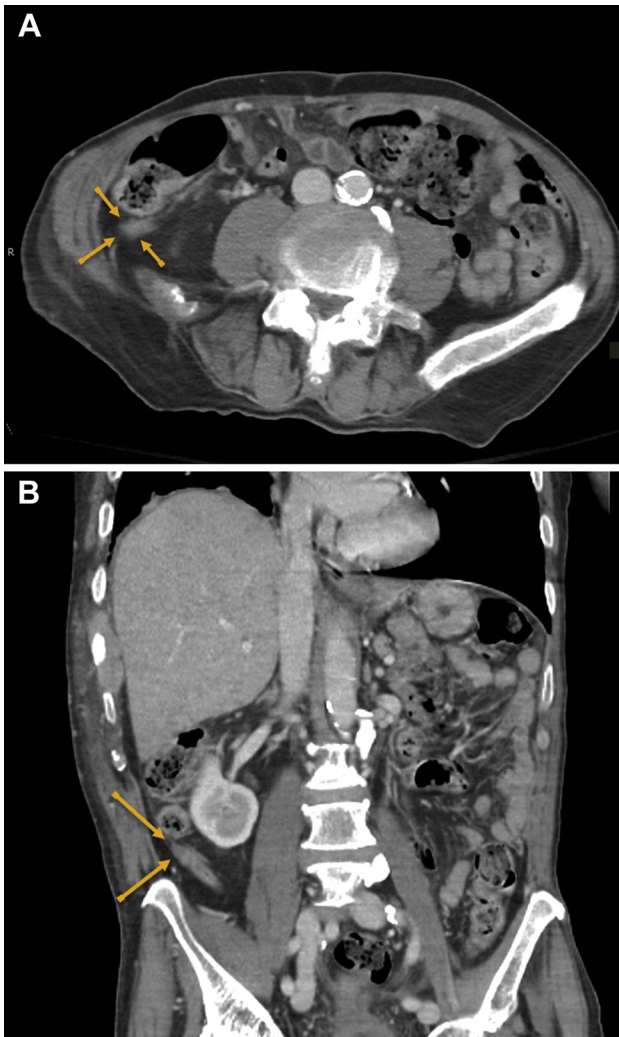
(A) Axial and (B) coronal computed tomography images of the abdomen revealing borderline dilated appendix measuring 9 mm in thickness (arrows), with mild associated wall thickening and minimal infiltration of the surrounding fat.
